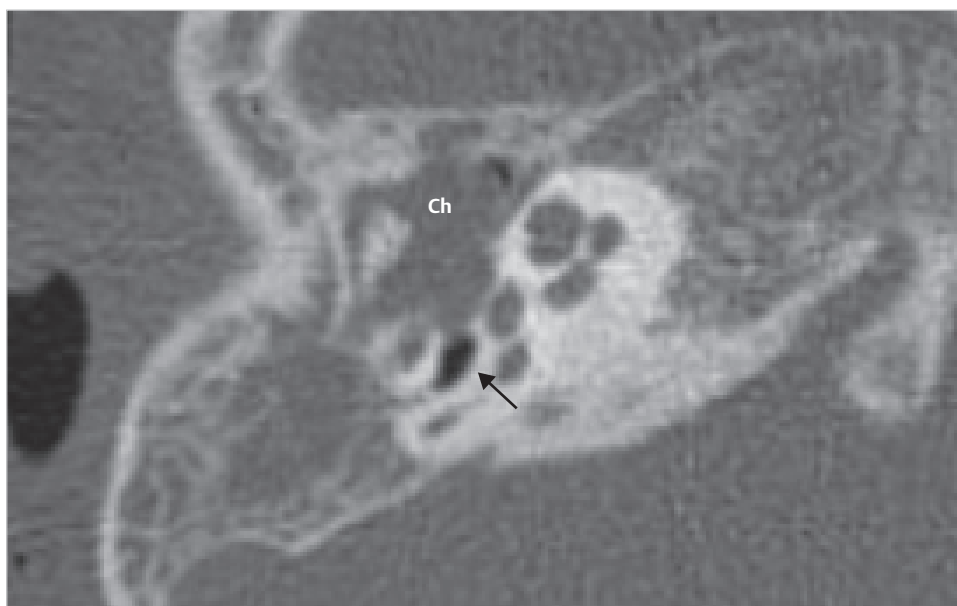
A case of large congenital cholesteatoma in the tympanic cavity. The axial CT demonstrates soft tissue density in the tympanic cavity and the mastoid, and absence of the long process of the incus and the superstructure of the stapes. Note that the tympanic sinus is free of disease, and ventilated (arrow). Ch, cholesteatoma.
